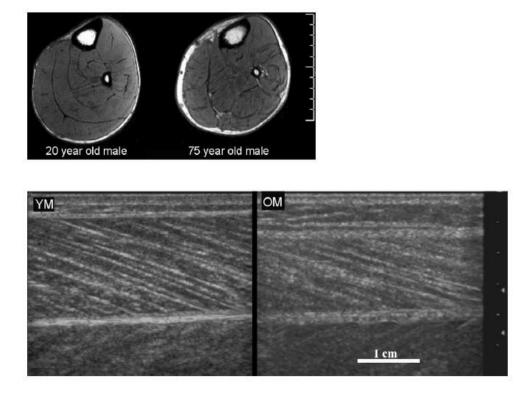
(Top) Axial-plane MRI scans of the calf muscles of a young male aged 20 years and an older male aged 75 years matched for anthropometric characteristics and physical activity level. (Bottom) Sagittal-plane sonographs of the gastrocnemius medialis muscle in the same subjects. In the older individual, muscle fibre fascicle length and pennation angle are visibly smaller than in the younger adult (from Narici et al., 2008).
